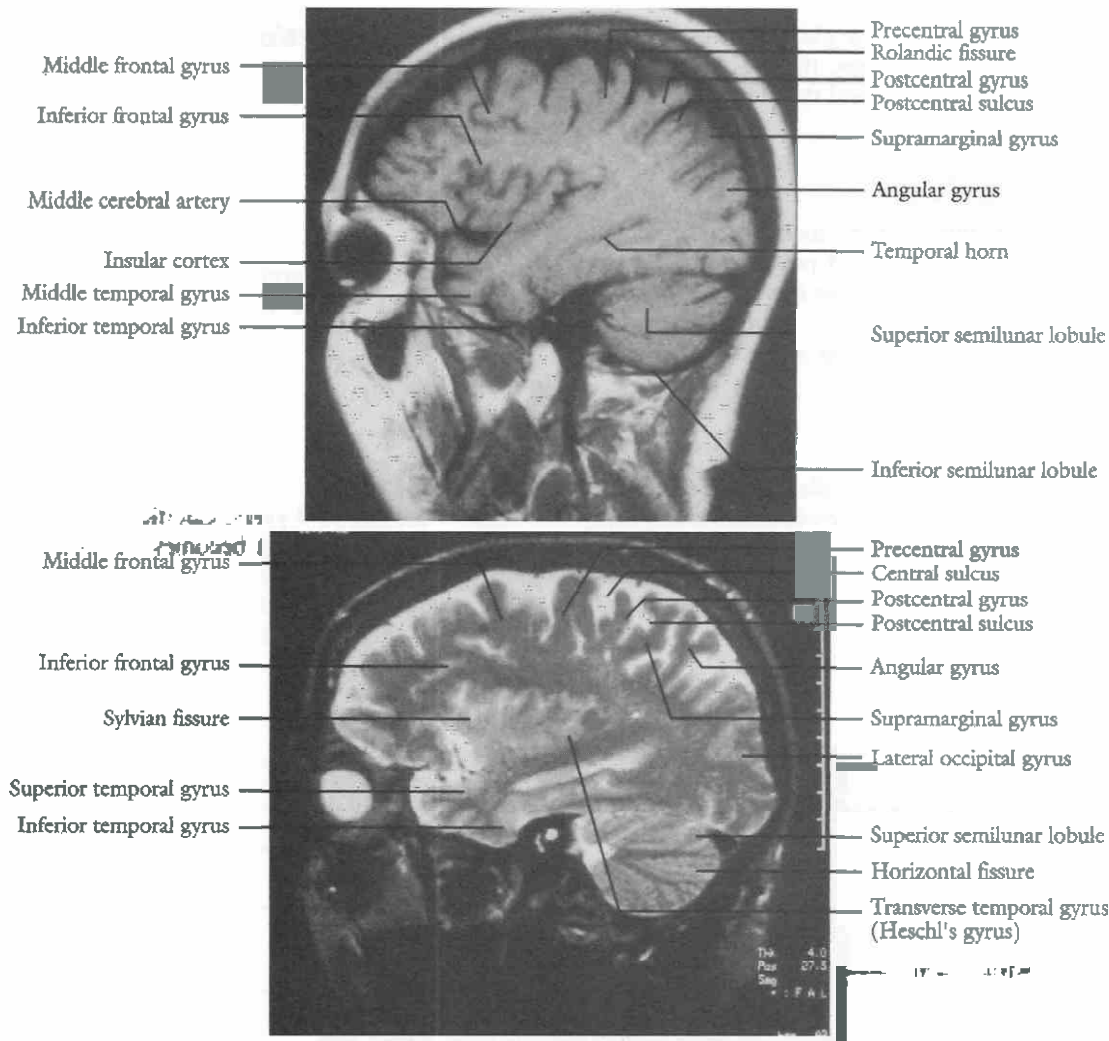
Top, Sagittal T1 MRI scan at the lateral orbital level. Bottom, Sagittal T2 MRI scan at the lateral orbital level
